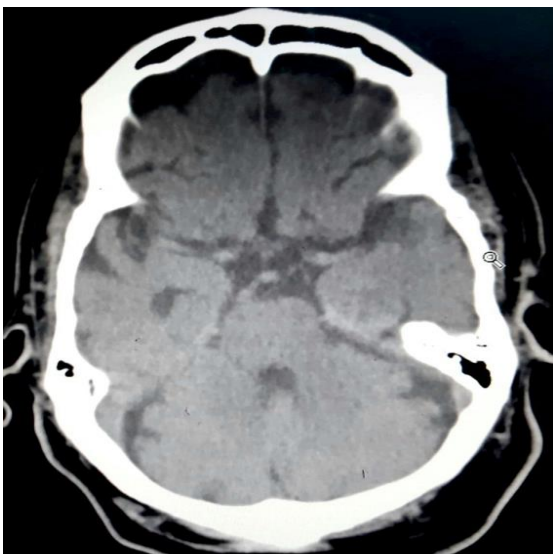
CT scan (in 2018) for the brain shows the basilar artery join the circle of Willis on the left side without making a bifurcation (brain window) both middle cerebral arteries appear hyper-dense.
